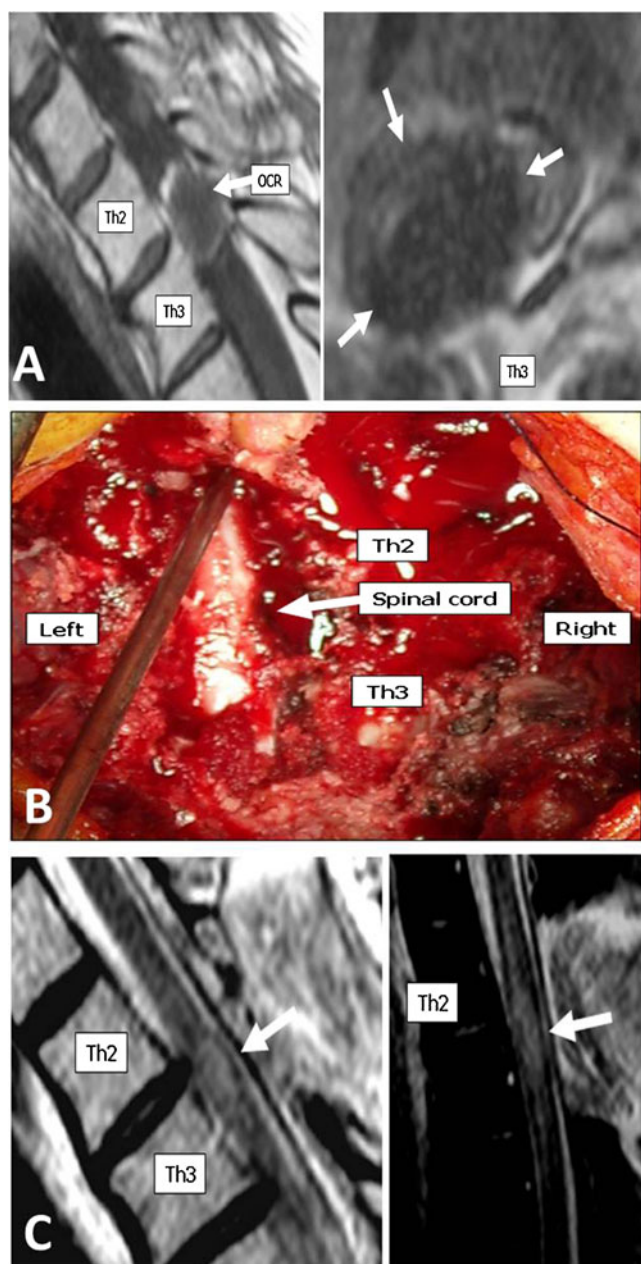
a MRI scan on admission: On the left, T1-weighted sagittal view, the “surgiceloma” (OCR) is visible as a hypointense mass with a hyperintense ring filling the spinal canal at the Th2-Th3 level (*arrow*). On the axial T2-weighted view shown on the right, there is a hypointense mass that appears to fill the intervertebral foramen and partially the spinal canal on the right (*arrows*). b Surgical site after Th2-3 laminectomy. The spinal cord is visibly thinned out from the right as a result of severe compression. c One week following surgery, the spinal cord showed signs of permanent damage. Arrows indicate the affected area as a hyperintense signal on T2-weighted imaging (*left*) and as a hypersignal on standard inversion recovery T2-weighted imaging (*right*)
